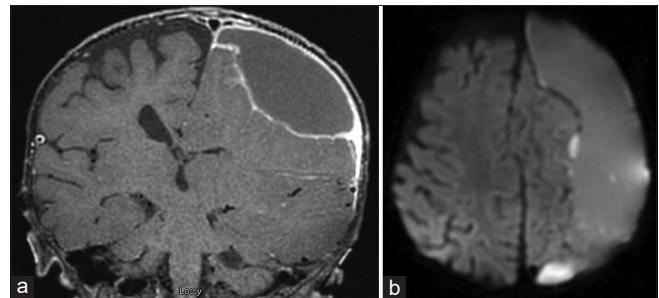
Preoperative MRI with coronal T1 postcontrast (a) and axial diffusion-weighted images (b) showing a large left subdural fluid collection concerning for hematoma with superimposed empyema and associated mass effect.
